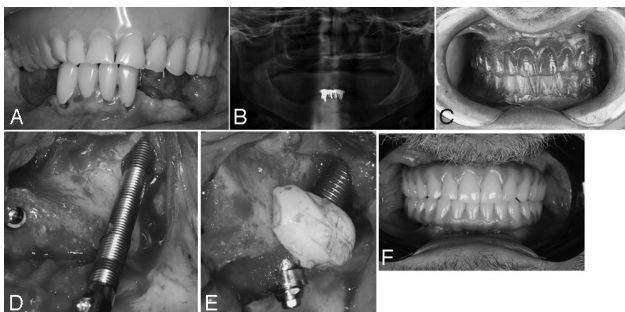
(A) Clinical aspect partially edentulous patients enrolled in this study. (B) Panoramic radiographic of edentulous patients. (C) Surgical guide and occlusal register. (D) Zygomatic implants placed extrasinus. (E) Connective tissue grafting was performed in the vestibular region of the zygomatic implant, with the intention of preventing gingival recession and/or inflammation. (F) Definitive prosthesis.
